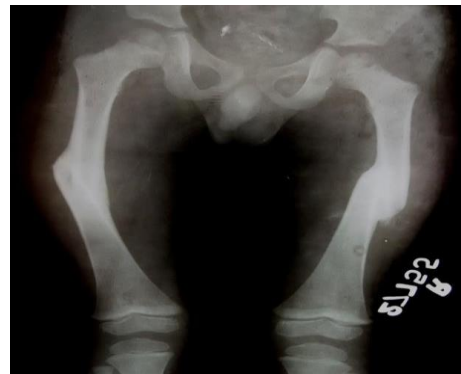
Radiograph of bilateral femur fracture at 7 months follow-up
